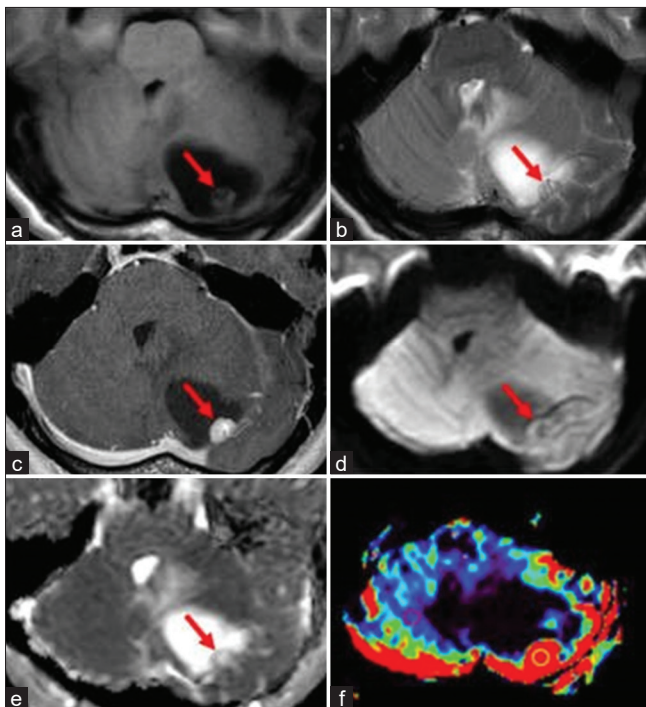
(a) Axial T1-weighted image (T1WI) showing a cystic mass lesion with a mural nodule in the left cerebellar hemisphere. (b) Axial T2WI showing flow voids (arrow) in the mural nodule. (c) Axial contrast-enhanced T1WI showing homogeneous enhancement of the mural nodule (arrow) and no enhancement of the cyst wall. (d) Axial diffusion-weighted image showing that the mural nodule (arrow) is low-intense. (e) A corresponding apparent diffusion coefficient (ADC) map showing increased ADC of the nodule (arrow). (f) PWI showing same cystic mass with mural nodule in red
